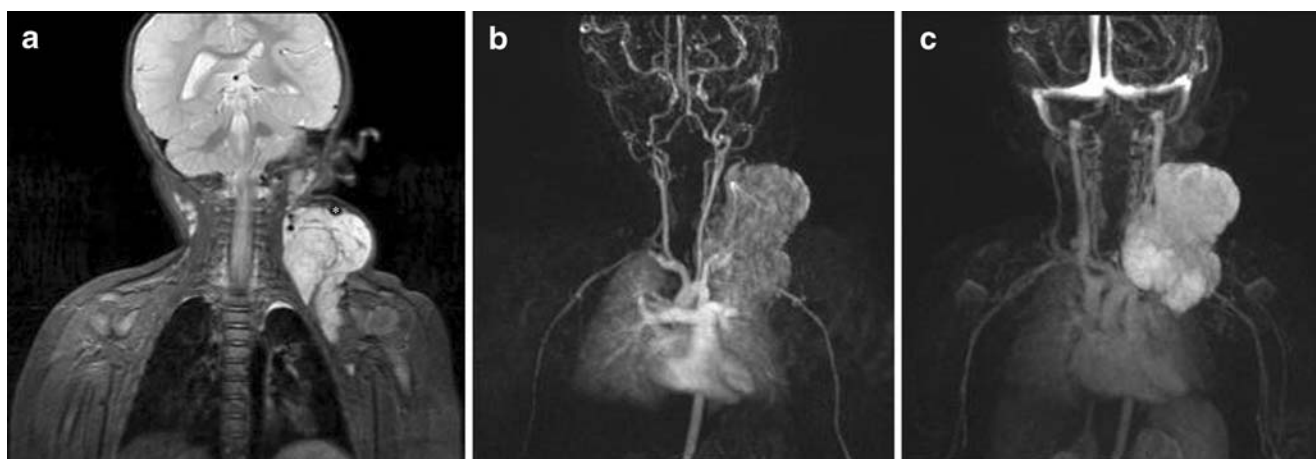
Congenital haemangioma in the left cervicothoracic region. MRI was performed in a 1-year-old boy with a cervical mass. (a) Coronal T2-W FS image shows a hyperintense mass in the left laterocervical region with caudal extension to the thoracic wall; flow voids (*asterisk*) representing arterial vessels are also seen. (b) and (c)
